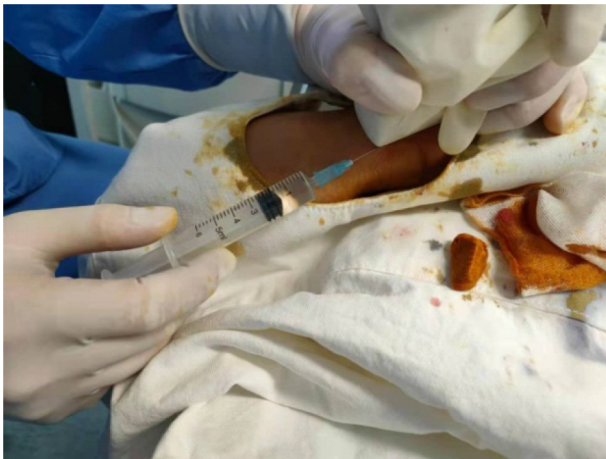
Sonographer held the probe covered with surgical gloves with one hand and did needle release of the superficial branch of radial nerve continuously under continuous guidance of ultrasound.
